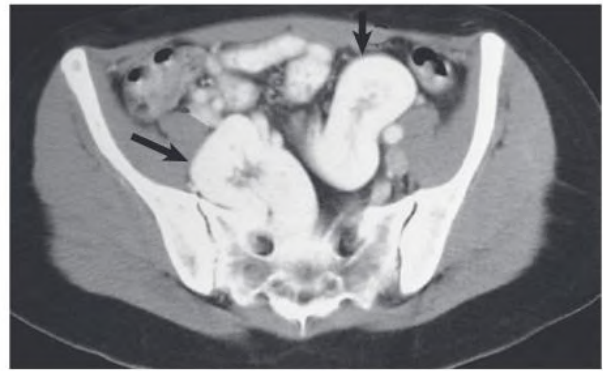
Bilateral pelvic kidneys (*arrows*) on computed tomography.
